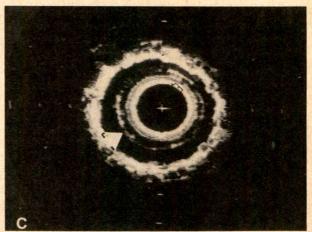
A, angiogram of left anterior descending artery stenosis after dissection (arrow) during percutaneous transluminal coronary angioplasty. B, angiographic appearance of left anterior descending artery lesion after stenting showing smooth contour. C, in vitro intravascular ultrasound examination of this vessel 24 hours after stenting (patient died from intracerebral hemorrhage 12 hours after stenting). The inner circle is due to intravascular probe. The outer echodense pattern is due to stent wires (large arrow). The lumen (small open arrow) is the echo-free space inside the stent. The stent effectively tacked back the dissection and restored the circular configuration of the vessel (courtesy of Dr. Bernardino Tucillo).
